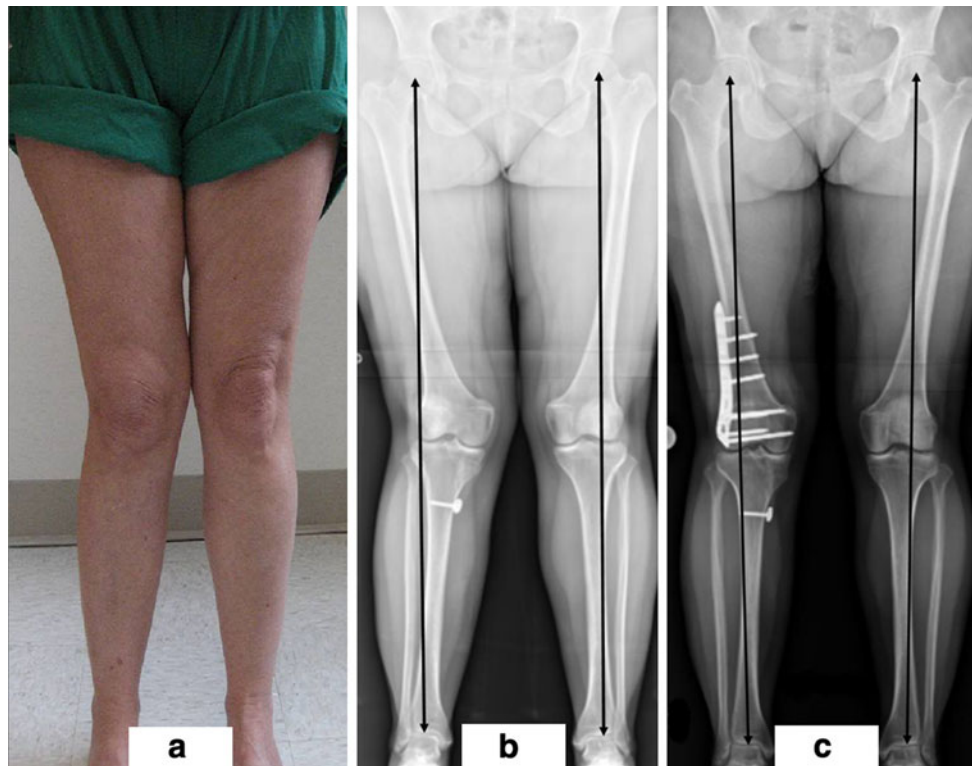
a Patient photograph showing increased valgus alignment of the *right* knee compared to the *left* knee. b Preoperative AP hip-to-ankle radiograph showing increased valgus alignment of the *right*
